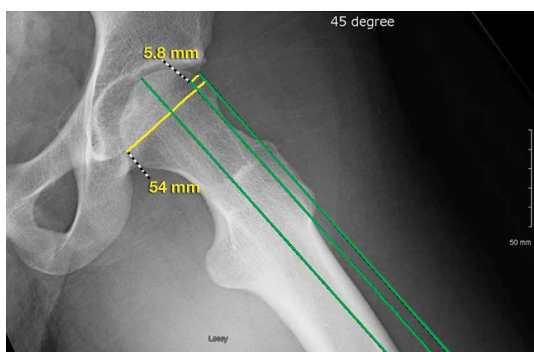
Femoral head–neck offset. Modified Dunn lateral radiograph (45° hip flexion) of an 18-year-old man shows measurements for femoral head–neck offset. Three parallel lines are drawn: center line of femoral neck, anterior-most cortex of femoral neck, and anterior-most cortex of femoral head. Distance between 2 anterior-most cortices (5.8 mm here) is divided by femoral head diameter (54 mm here) to obtain femoral head–neck offset (0.11). In many cases, cam deformity is present with head–neck offset ratio <0.17.
